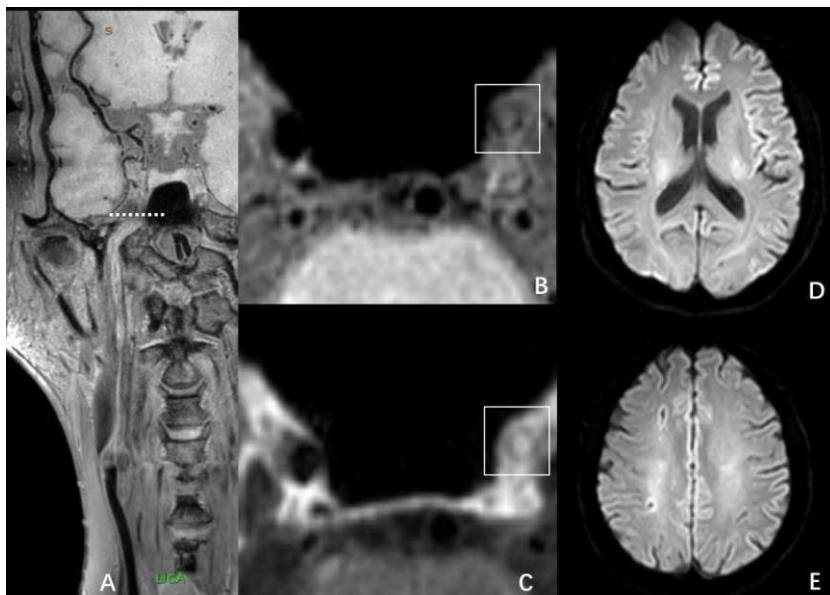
The multiple planner reconstruction of occluded left carotid internal artery (A) and its axial images (B and C) before and after injecting contrast agent. No hemorrhage in the entry or HIS in the route were observed. The occlusion was found involving the C6 segment and Inhomogeneous enhancement in the lumen. No infarct was found on brain DWI images (D and E).
